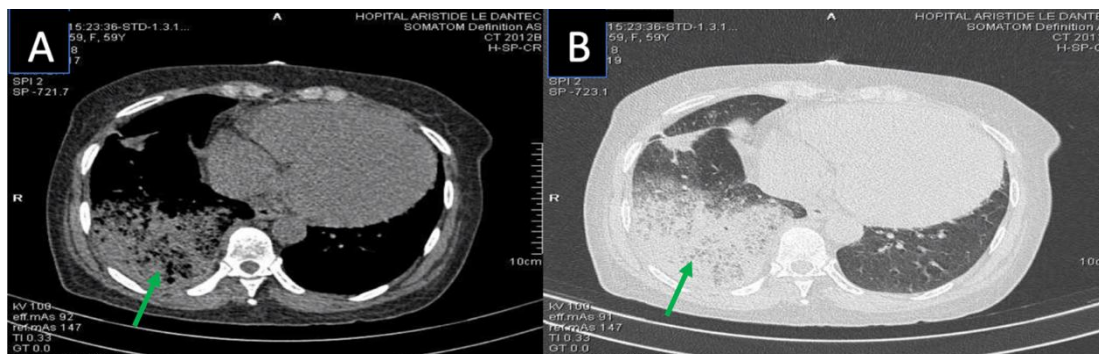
Axial CT sections without contrast injection in the mediastinal window (A) and parenchymal window (B) showing a pulmonary condensation site at the right pulmonary base (green arrow), heterogeneous with aerial formations, without air bronchogram in relation to a pulmonary infarct site.
